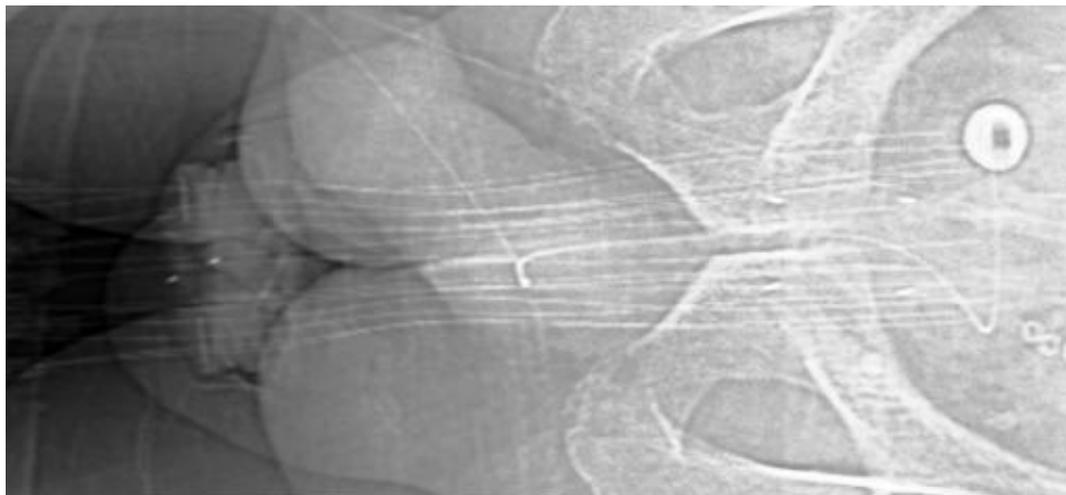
Coronal CT reconstruction showing deformation of implanted plastic needles after metal obturators were replaced with custom-made flexible wires. See text for details.
